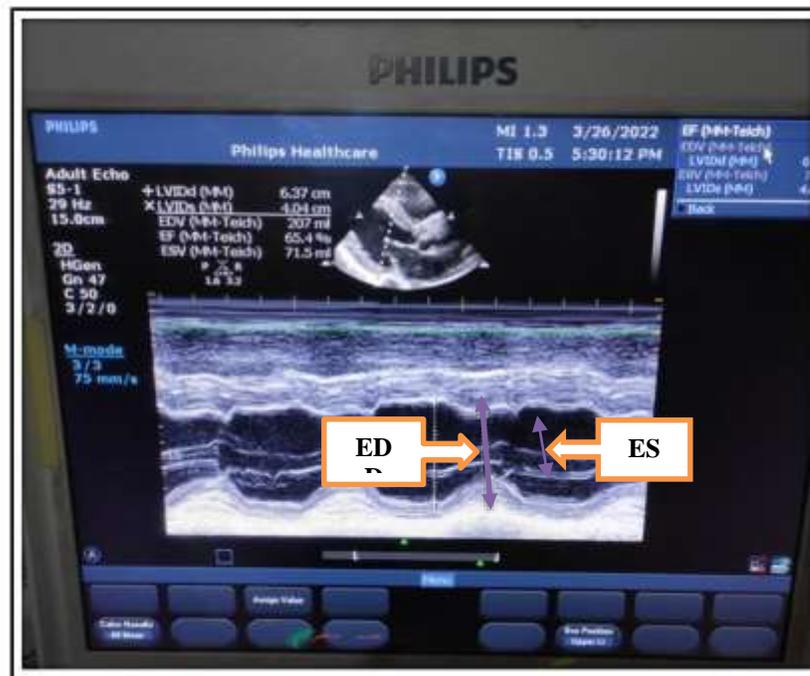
Left ventricular M-mode measurements: parasternal long axis view.
